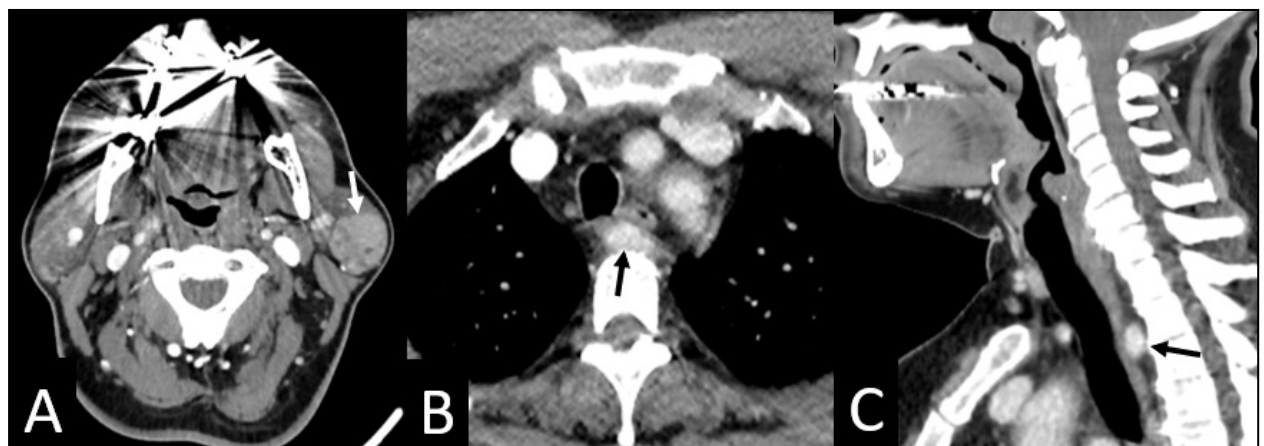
Contrast-Enhanced CT Neck. A: soft-tissues mass in the left parotid gland (white arrow). B, C: the axial and sagittal views demonstrate an aberrant right subclavian artery (black arrows).
